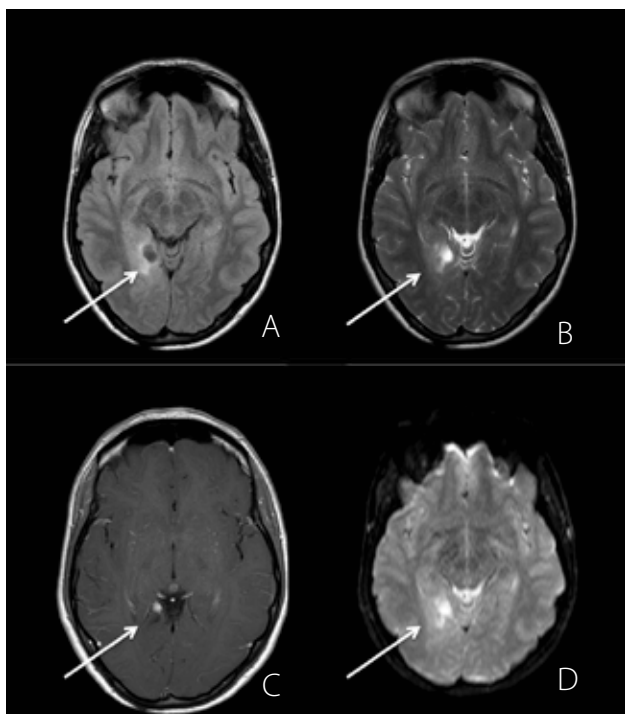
MR Brain Axial Images: FLAIR (A), T2 (B), post-contrast T1 (C) and DWI (D) weighted imaging demonstrating enhancing lesion with cystic component (arrow) involving the medial aspect of the right occipital lobe.
